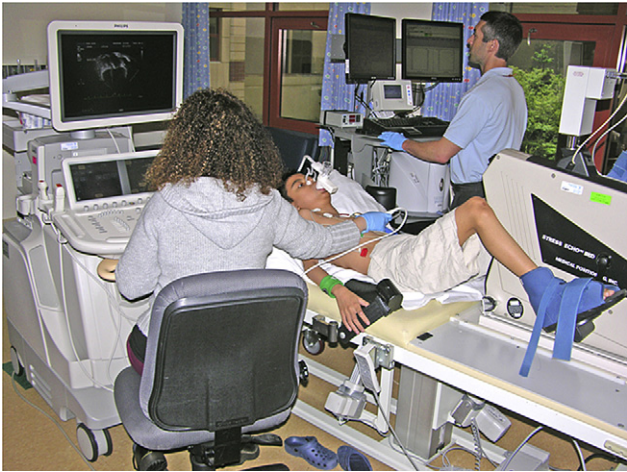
Setup for simultaneous exercise supine cycle ergometry. The sonographer imaged subjects during exercising.
